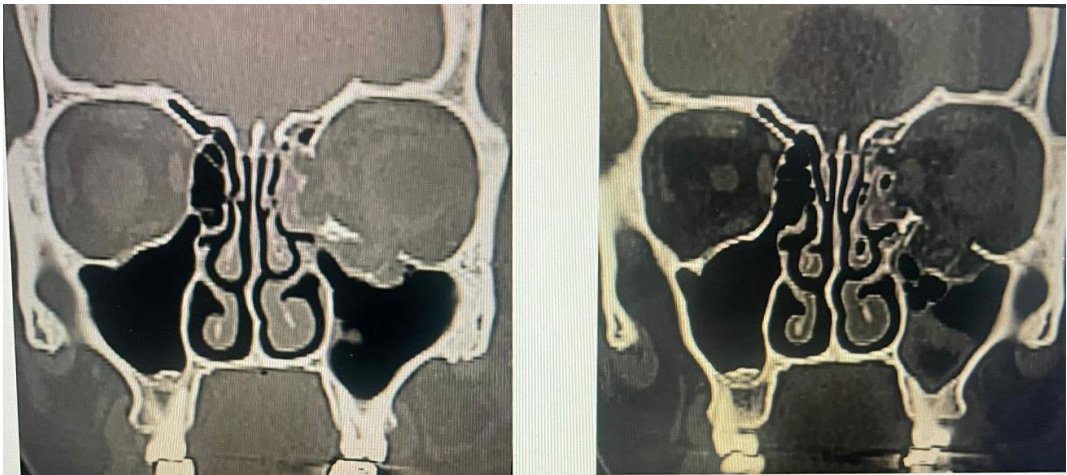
Orbital floor fracture in 8 year 8-year-old patient in coronal CT scan
